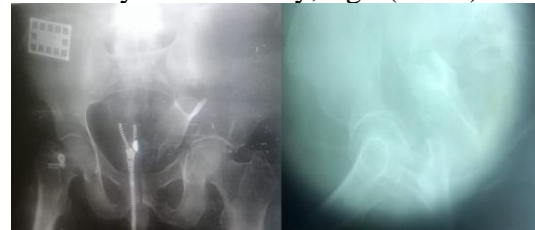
Preoperative plain X-ray antero-posterior and iliac view showing avulsion of the posterior column.
